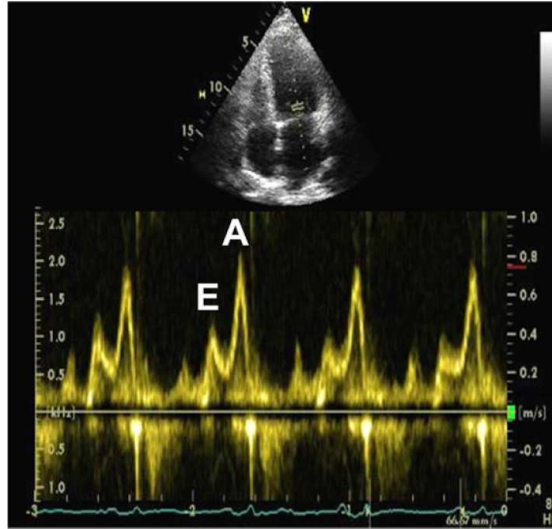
2-D Doppler Echocardiogram of a patient with impaired relaxation pattern (16)
